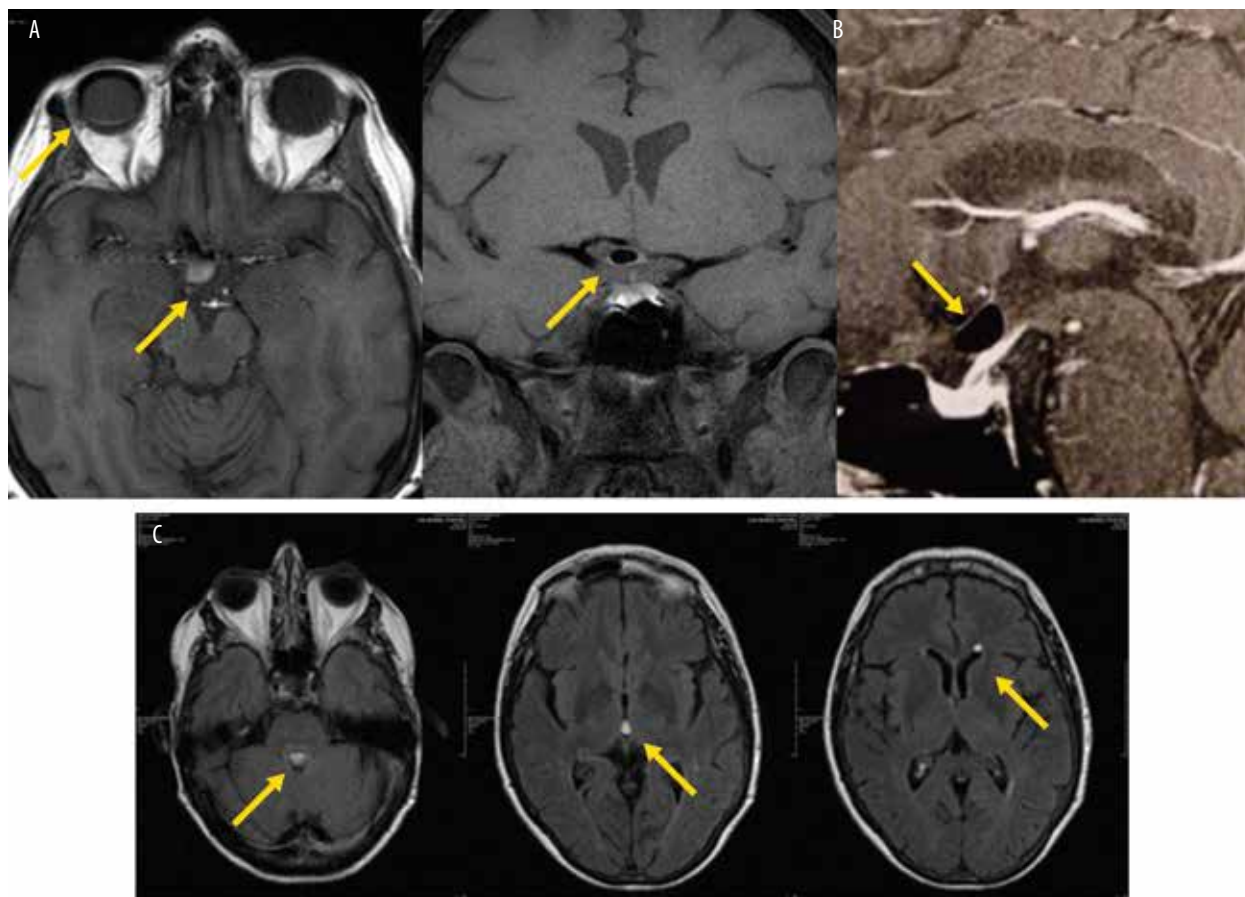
Brain MRI. (A) Axial T1-weighted image showing SO in right vitreous cavity, optic nerve and chiasm. (B) Coronal and sagittal T1-weighted, fat suppressed and gadolinium images showing SO inside the chiasm. (C) Axial T1-weighted images with the SO in fourth, third and lateral ventricles. Arrows indicate the location of silicone oil.
